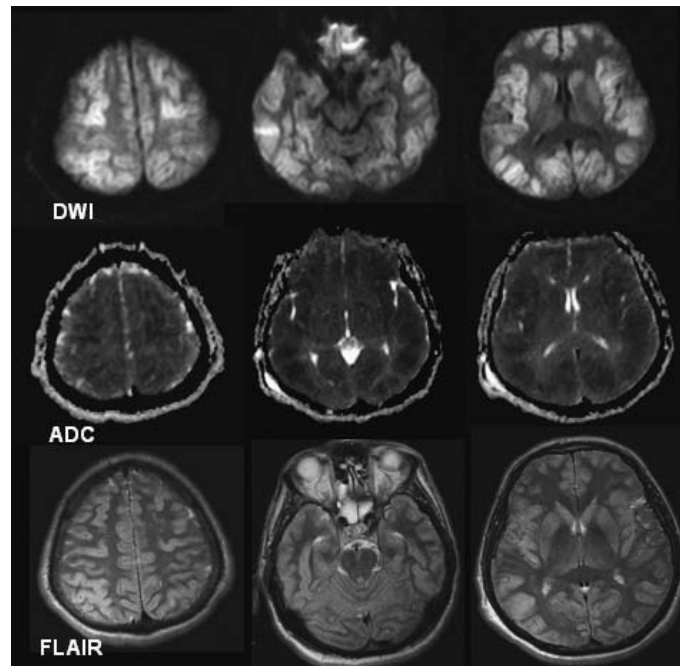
Representative example of extensive cortical (plus subcortical) injury pattern. Lesions are bright in DWI (diffusion-weighted imaging) (upper row), dark in ADC (apparent coefficient mapping) (middle row) and hyperintense in FLAIR (fluid attenuated inversion recovery) sequences (bottom row).
